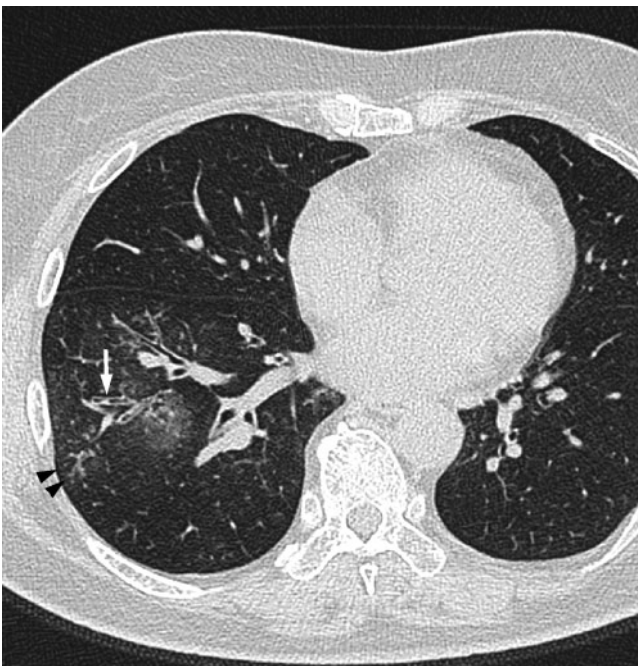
Acute *Haemophilus influenzae* infection in a 55-year-old man with a smoking habit at 3 days after onset of fever and cough. A transverse thin-section CT of the left lower lobe shows consolidation, ground-glass opacity, bronchial wall thickening (arrow) and centrilobular nodules (arrowheads).
